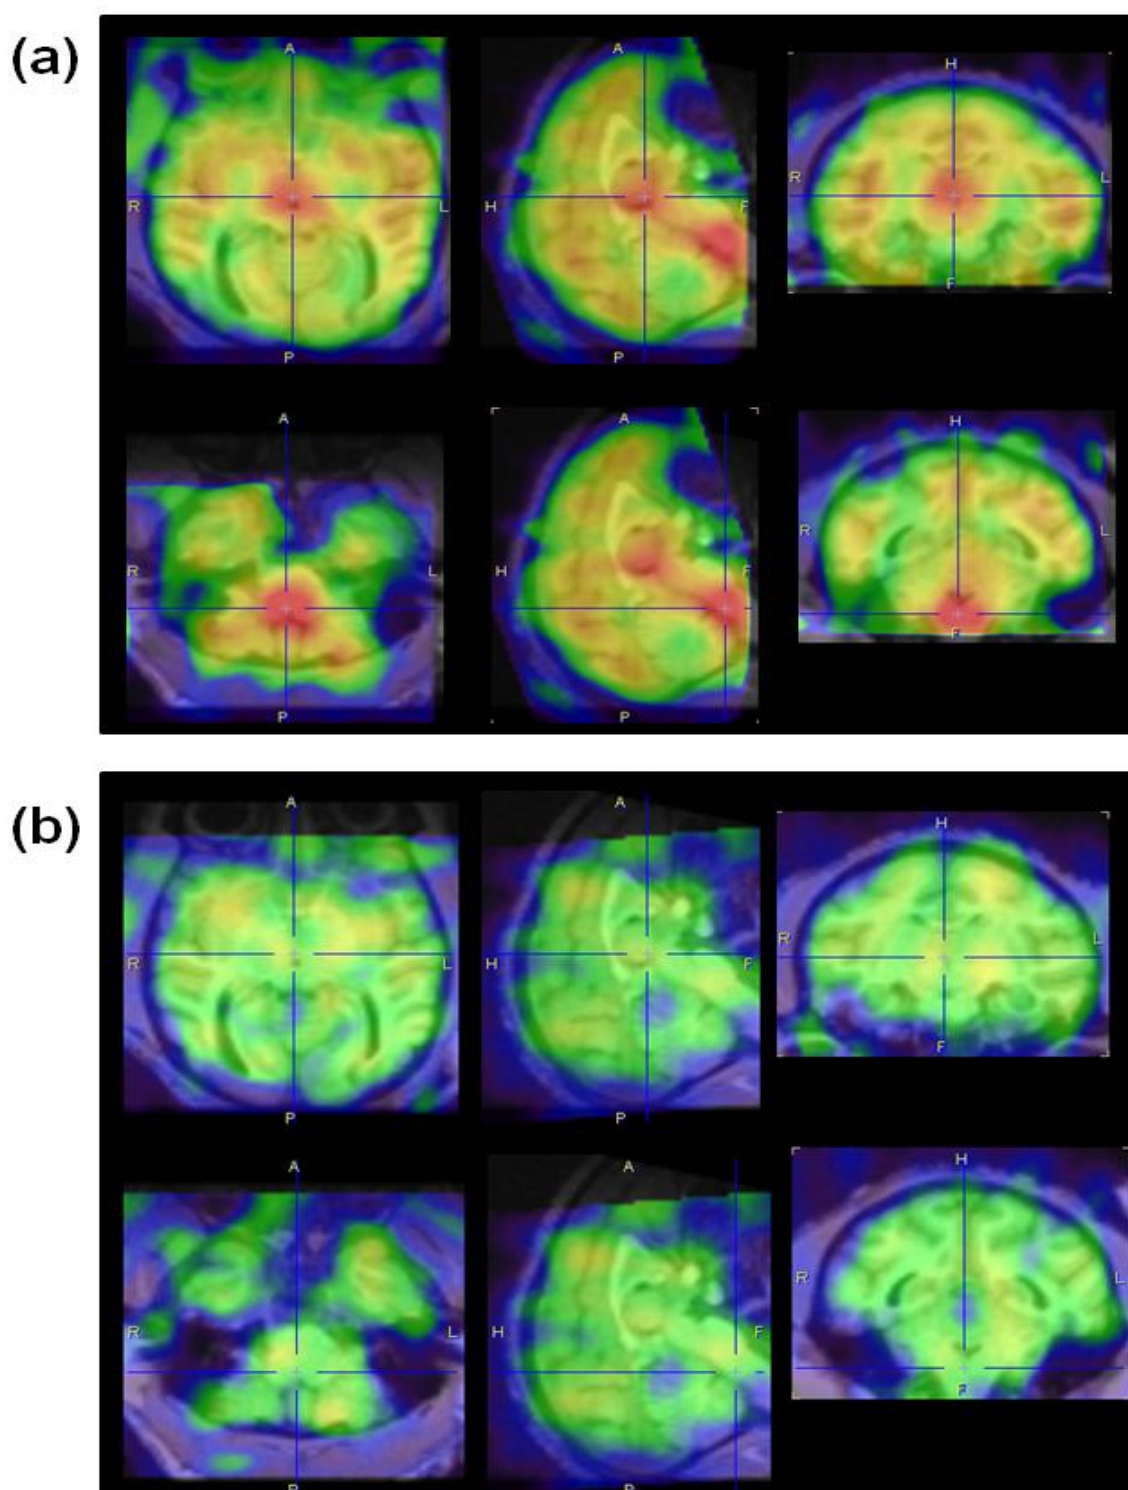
^{123}I -INER brain SPECT images co-registered with MRI (transverse, sagittal and coronal planes from left to right), showing the distribution at baseline (a) and following pre-blocking with atomoxetine (b).
